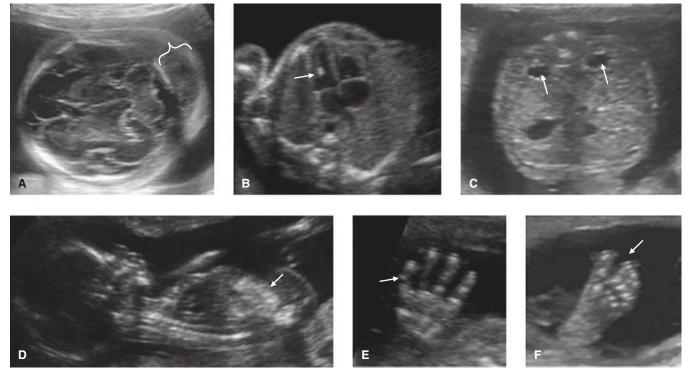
Minor sonographic markers that are associated with increased risk for fetal Down syndrome. A. Nuchal skinfold thickening (*bracket*). B. Echogenic intracardiac focus (*arrow*). C. Mild renal pelvis dilatation (pyelectasis) (*arrows*). D. Echogenic bowel (*arrow*). E. Clinod-actyly—hypoplasia of the 5th finger middle phalanx creates an inward curvature (*arrow*). F. "Sandal-gap" (*arrow*).
